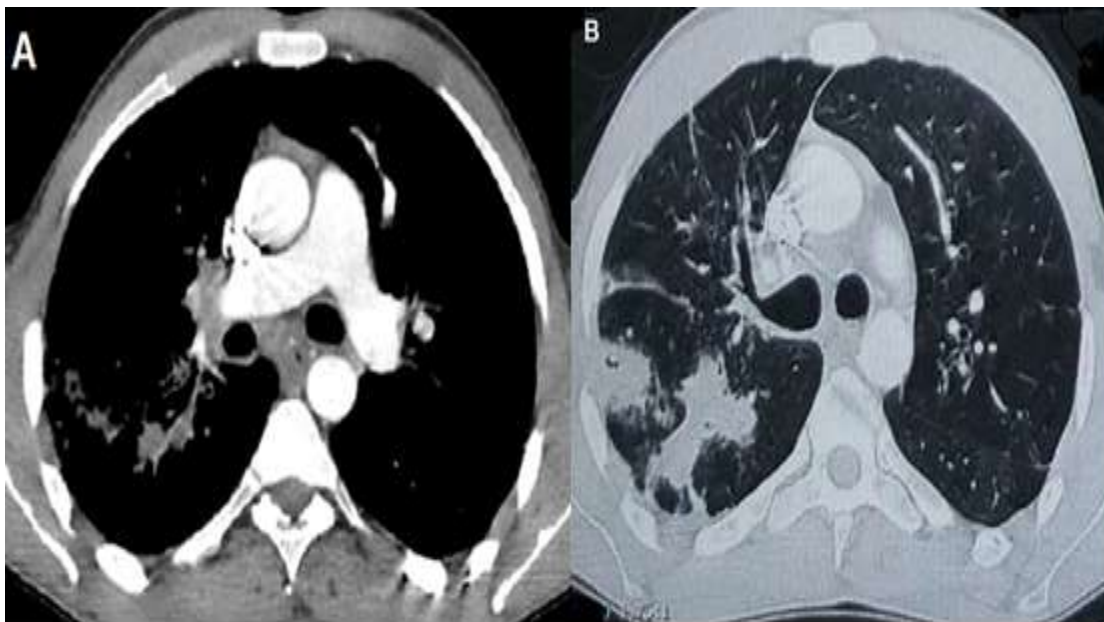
(A) Mediastinal window and (B) parenchymal window images of CT scan showing a thrombus in the right upper lobar pulmonary artery and excavated lesion of the right lower lobe.
